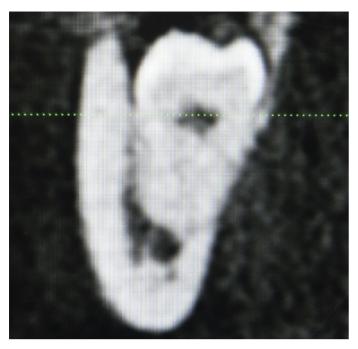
Cone beam computed tomography coronal view demonstrating the inferior alveolar nerve coursing through the apical third of tooth #32.
